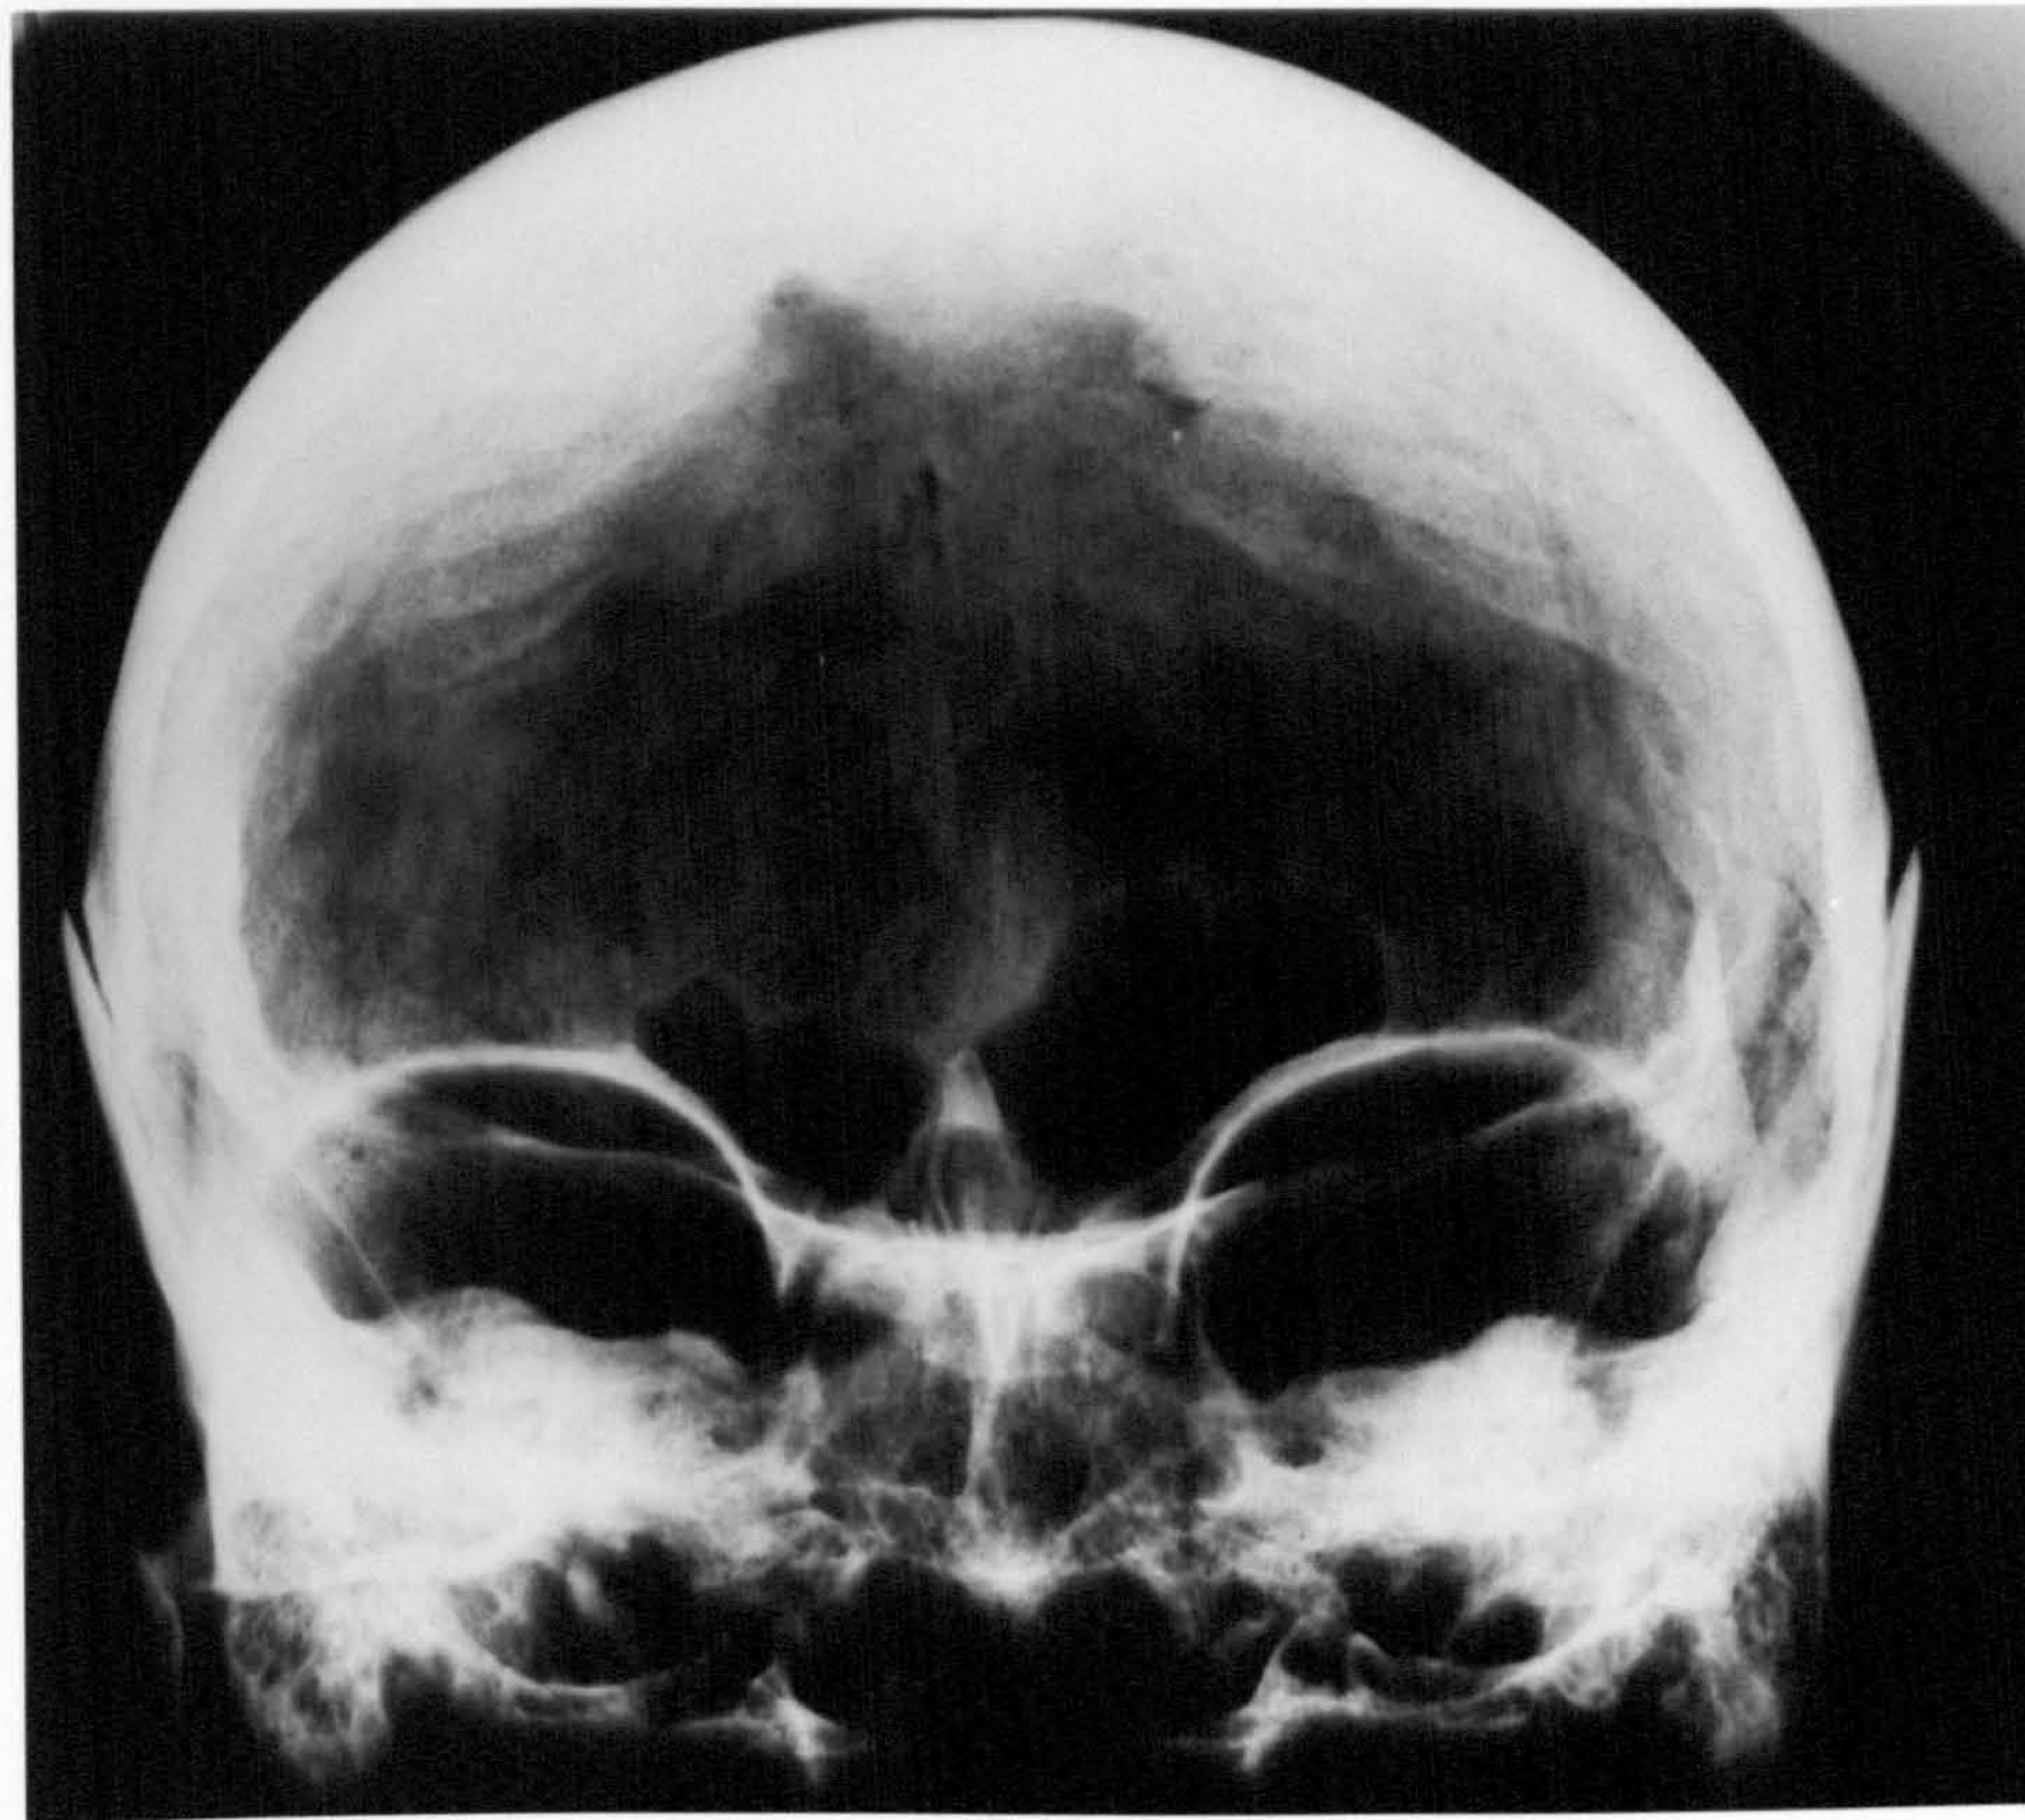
Typical appearance of hyperostosis frontalis interna (HFI) in a modern x-ray
